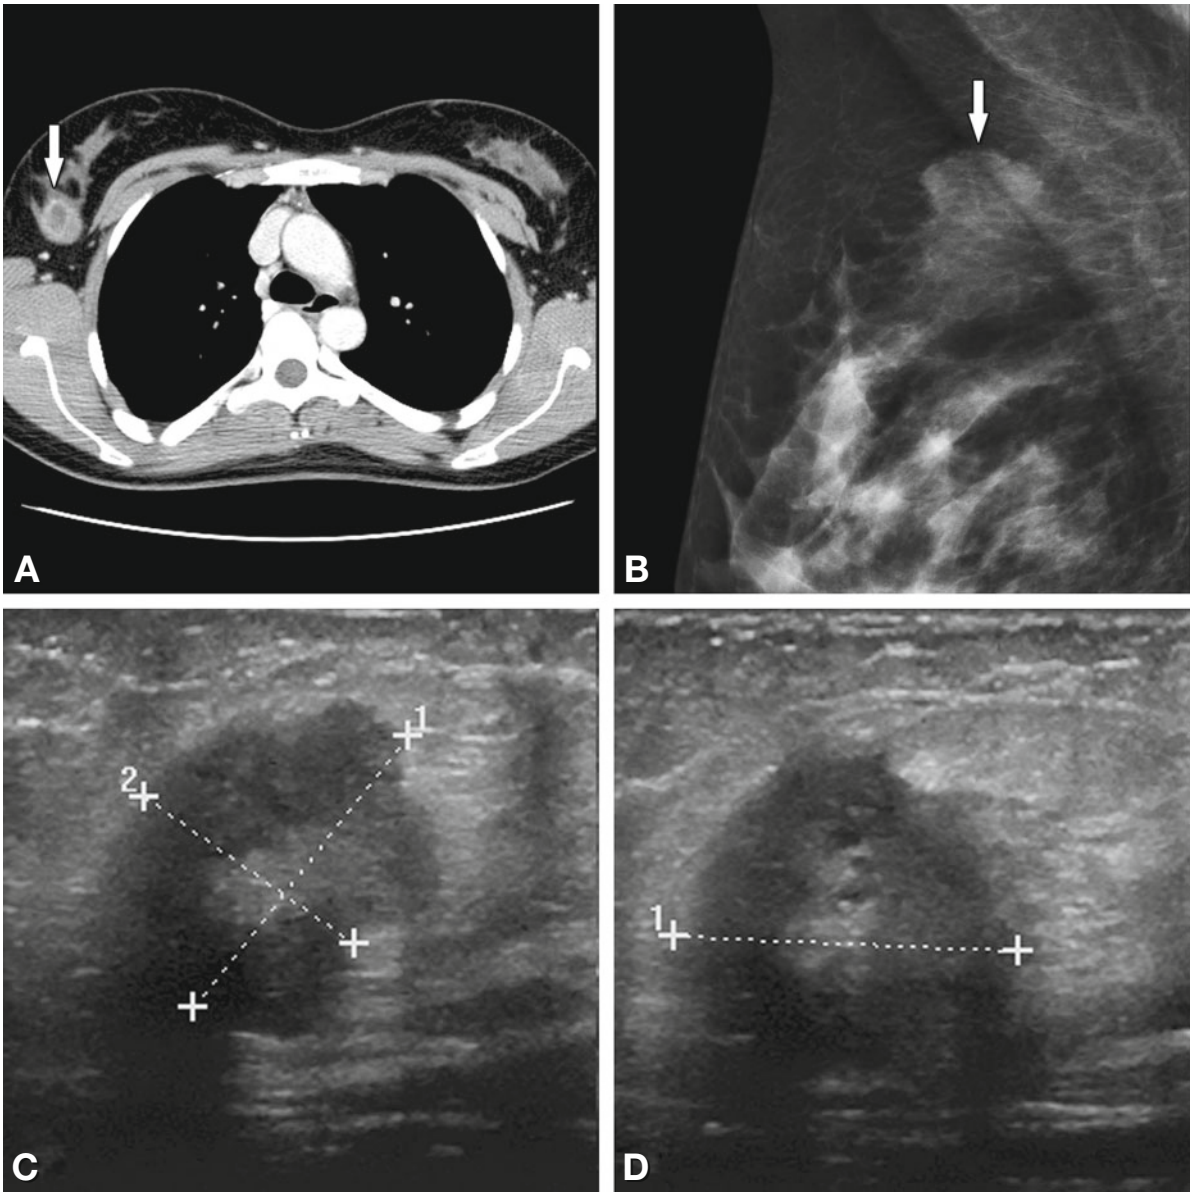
Incidental finding of a well-vascularized 2-cm cancer in the upper outer quadrant of the right breast on chest CT in a 28-year-old female patient who presented with shortness of breath (*arrow* in Panel A). Panel B shows the tumor (*arrow*) on a magnified mediolateral oblique view mammography. Panels C and D are sonography images with measurements
